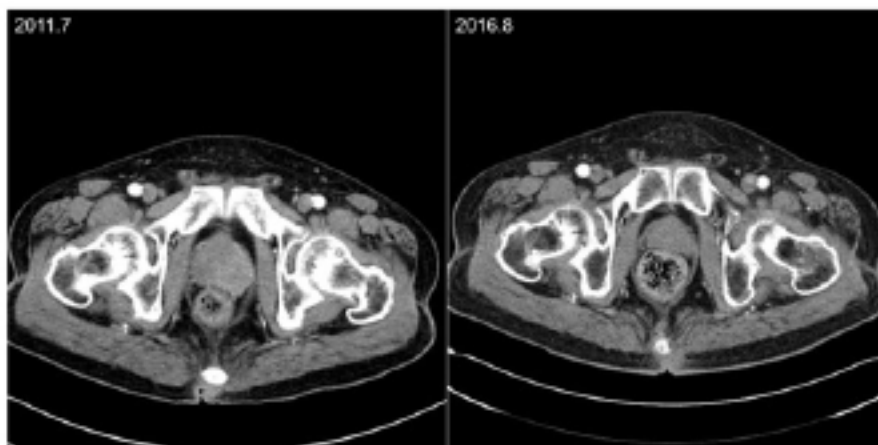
Computed tomography findings during treatment.
